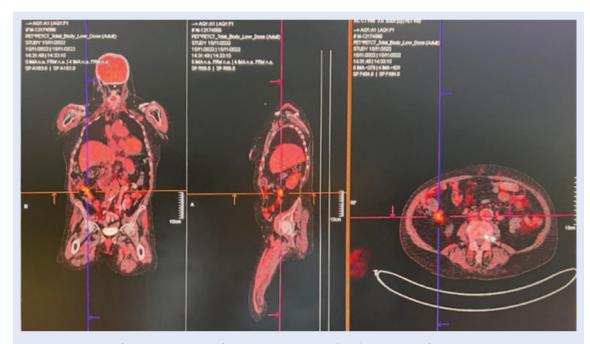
PET scan – focal accumulation of radiopharmaceuticals (FDG) in the area of cecoascending transition and the appendix
